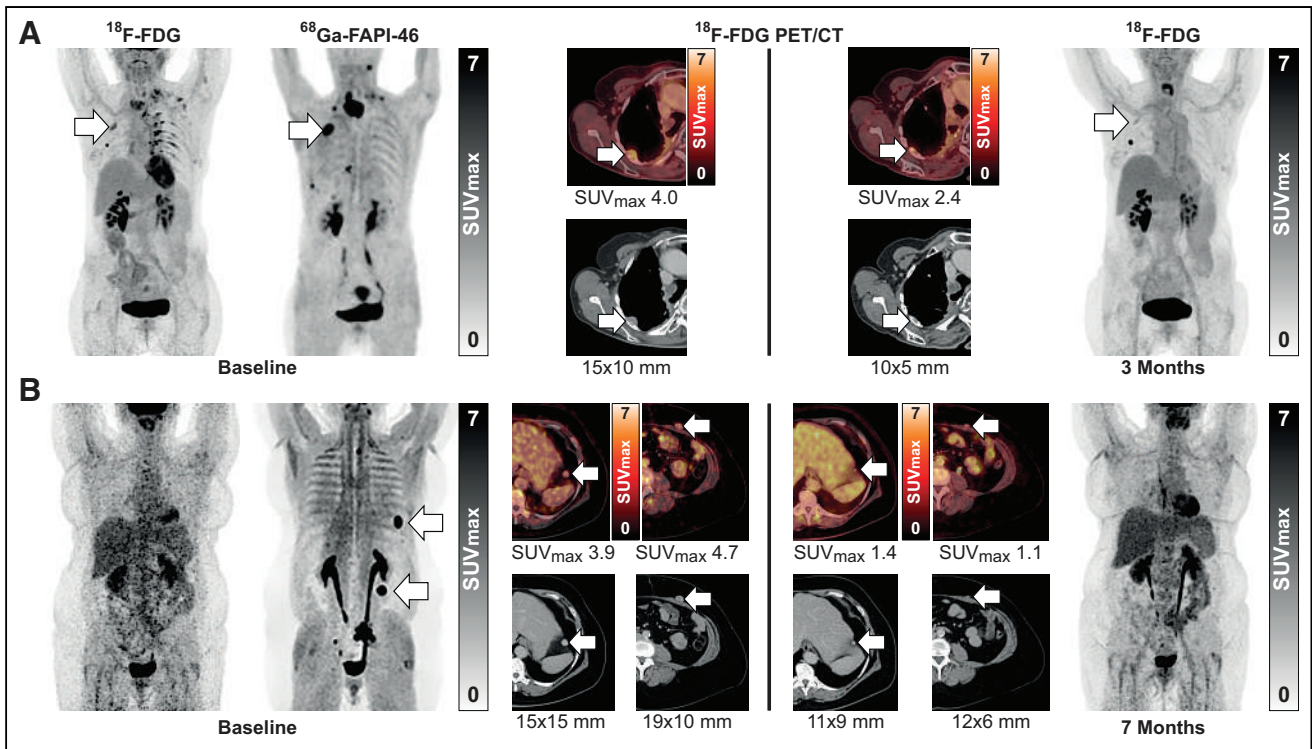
Patients with partial response after ^{90}Y -FAPI-46 RLT. At far left and right are maximum-intensity PET projections, and at center are axial ^{18}F -FDG PET/CT (top rows) and CT (bottom rows) images, with SUV_{max} and tumor diameter, respectively, before therapy (left) and at time point of best response (right). (A) 67-y-old woman (patient 2) with metastatic SFT who progressed under 3 lines of systemic therapy, with RECIST partial response and PERCIST partial metabolic response under RLT. ^{90}Y -FAPI-46 RLT was discontinued because of relapse of metastatic breast cancer in liver and lung. (B) 57-y-old woman (patient 5) with metastatic SFT who progressed under 2 lines of systemic therapy, with RECIST partial response and PERCIST stable metabolic disease under RLT.
